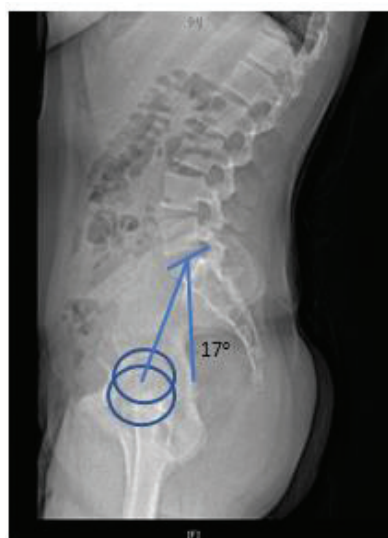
Pelvic tilt. (1) Draw a line from the midpoint of the sacral end plate running perpendicular down to the bottom of the X-ray. (2) Draw a line from the center of the femoral heads to the center of the sacrum. (3) The angle between these two lines is the pelvic tilt. This individual's pelvic tilt measures 17°.
